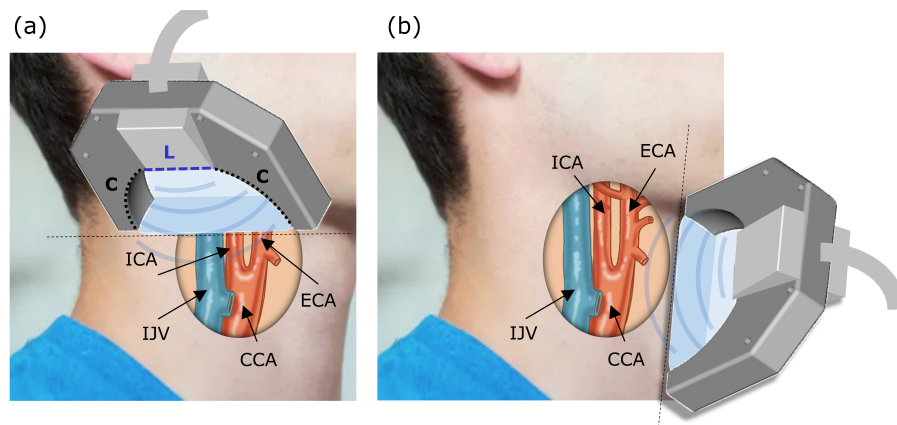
Geometry of the multimodal (MSOT, pulse-echo US, and color Doppler) image acquisition with the multi-segment probe in (a) transverse and (b) longitudinal planes. ICA: internal carotid artery; ECA: external carotid artery; IJV: internal jugular vein; CCA: common carotid artery.
